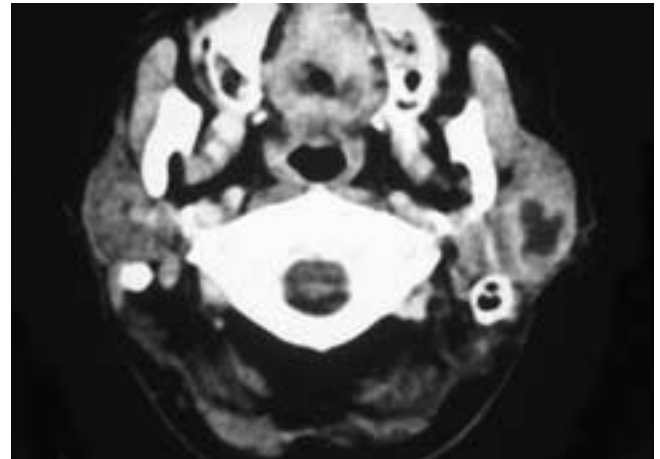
Axial contrast-enhanced CT scan shows a necrotic, irregularly walled, invasive tumor in the left parotid gland. This patient had an adenocarcinoma.
